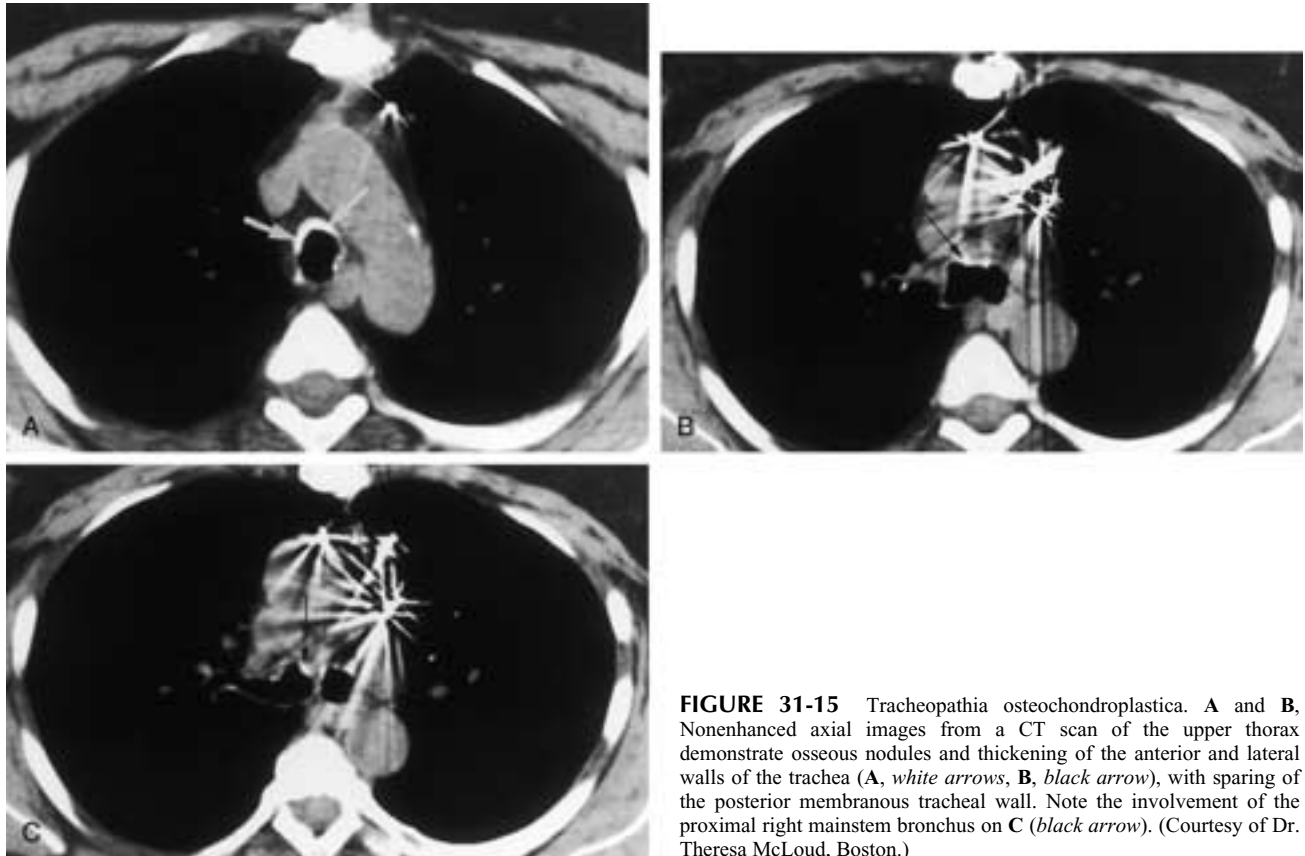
Tracheopathia osteochondroplastica. A and B, Nonenhanced axial images from a CT scan of the upper thorax demonstrate osseous nodules and thickening of the anterior and lateral walls of the trachea (A, white arrows, B, black arrow), with sparing of the posterior membranous tracheal wall. Note the involvement of the proximal right mainstem bronchus on C (black arrow). (Courtesy of Dr. Theresa McCloud, Boston.)
